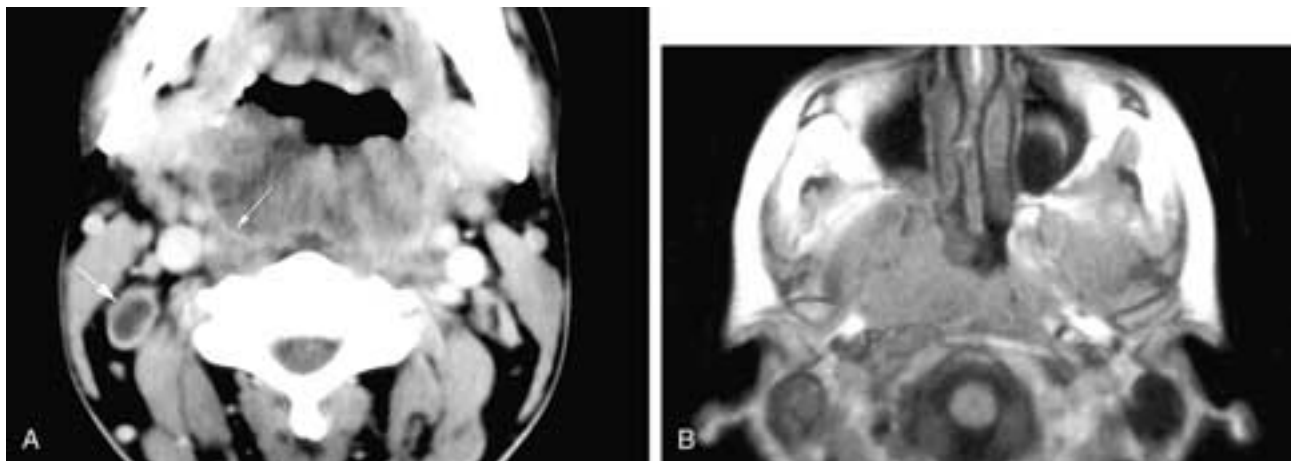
Axial contrast-enhanced CT scan (A) shows a large, bulky tumor in the pharynx. The visceral fascia around the pharyngeal constrictor muscles can be seen containing the tumor (*small arrow*). This imaging appearance is not uncommon with pharyngeal tumors and often belies the malignant nature of the tumor. However, a necrotic right level II node is present (*large arrow*), attesting to the aggressive nature of the cancer. Axial T1-weighted MR image (B) shows an infiltrative nasopharyngeal tumor that has violated the visceral fascia. The penetration of this fascia signifies the aggressive nature of the carcinoma.
